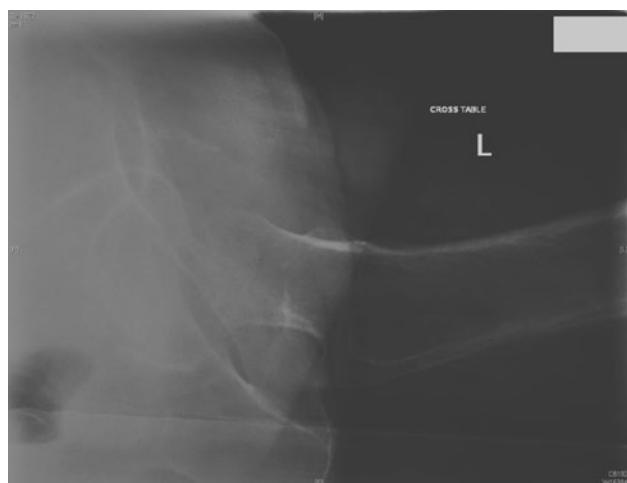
Lateral radiograph of a subcapital fractured neck of femur
